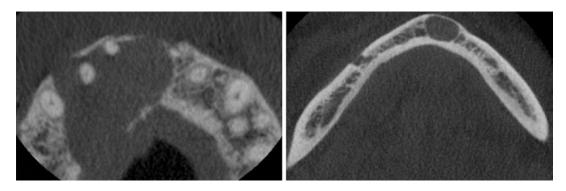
A: Secondarily Infected Radicular Cyst/B: Residual Cyst. A: Axial CBCT slice reveals the destruction of the buccal and palatal cortical plates of the maxilla. Although odontogenic cysts cause expansion instead of destruction, secondarily infected cystic lesion cause more aggressive lytic patterns. B: Axial CBCT slice reveals unilocular hypodense lesion with hyperdense corticated welldefined border at edentulous site
